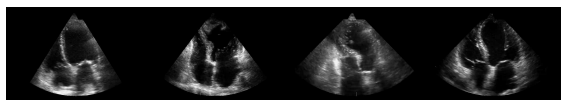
Apical four-chamber echocardiogram images from different subjects.
